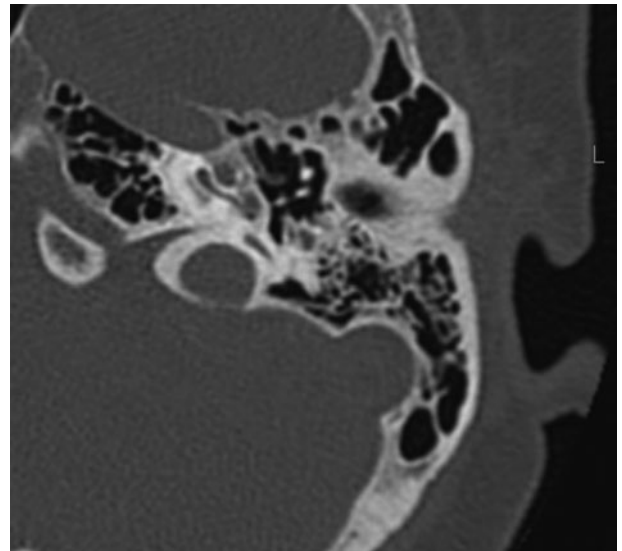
High-resolution cone-beam computed tomography of left temporal bone demonstrating round window ossification with fenestral and retrofenestral otosclerosis. The basal turn (incompletely visualised in this image) also narrowed.
